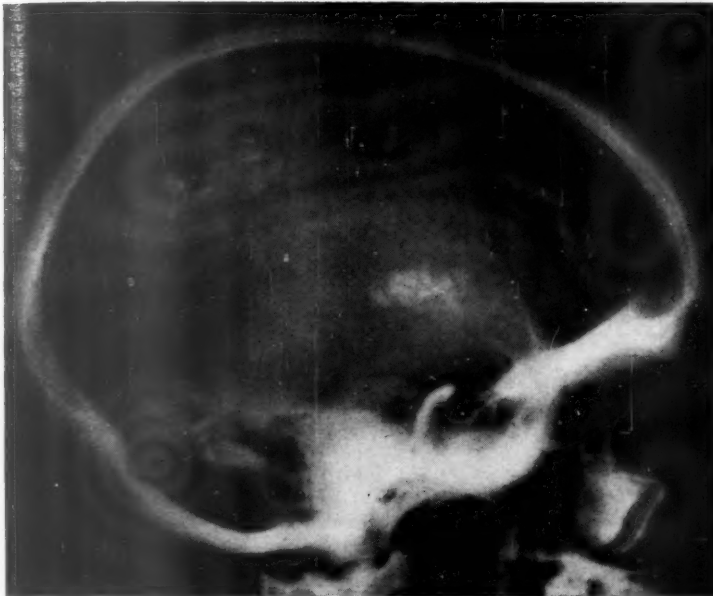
Lateral radiograph of skull of A.P., showing distribution of calcification.
